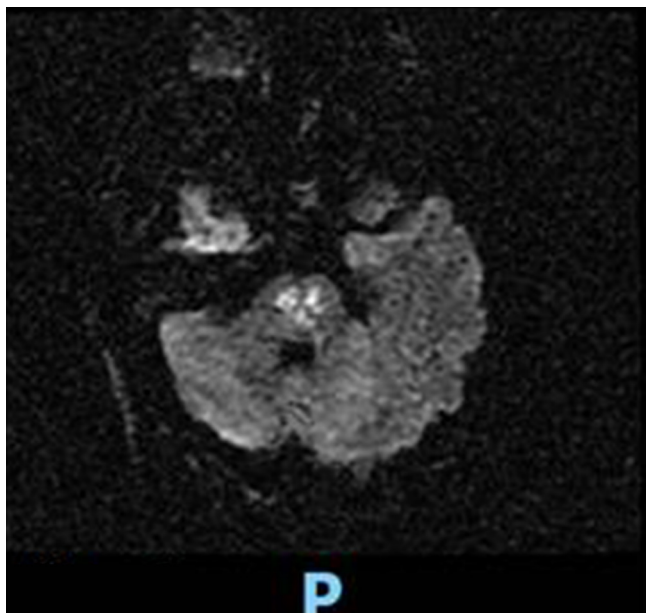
MRI brain-DWI sequences showing acute bilateral pontine strokes.
